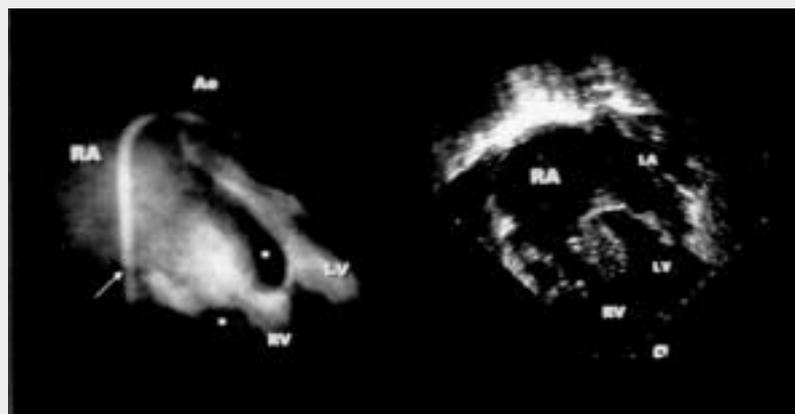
Angiographic (left panel) and echocardiographic (right panel) imaging of the Ebstein's anomaly of the tricuspid valve. Left ventricular angiography was performed in the 4-chamber view, in order to image the mid-muscular ventricular septal defect. Note the dysplasia and redundancy of both mural and posterior leaflet of the tricuspid valve (asterisks) that appear severely downward displaced with respect to the valvular annulus (white arrow). It results in severe tricuspid valve regurgitation and marked hypoplasia of the functional right ventricular chamber. Ao = aorta; LA = left atrium; LV = left ventricle; RA = right atrium; RV = right ventricle.
